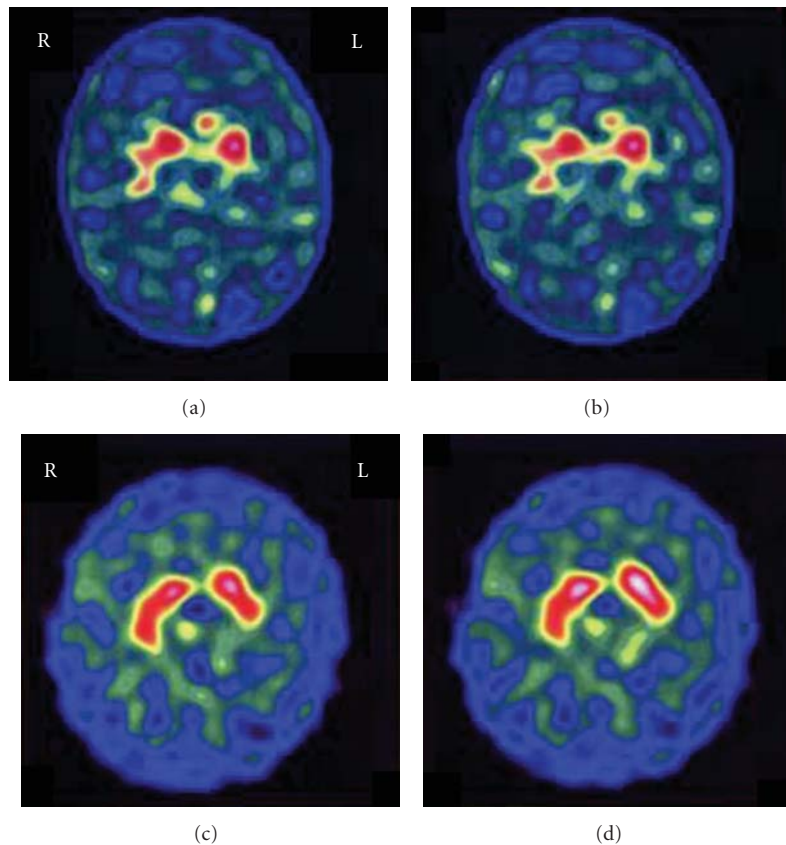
(a,b) representative ^{99m}Tc -TRODAT-1 SPECT images of an IAD subject in comparison with an age-matched healthy control ((a) a 20-year-old male IAD subject; (b) a 20-year-old male healthy control). Left hemisphere is on right side of image. The IAD subject demonstrates a significant decrease in binding of ^{99m}Tc -TRODAT-1 to the DAT in the striatum and the bilateral corpus striatum is much smaller and more irregular than that in the control.
